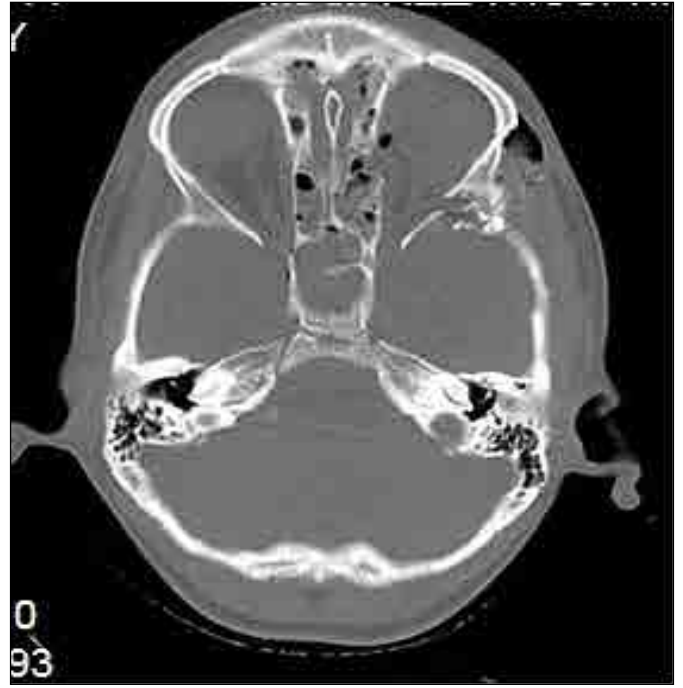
Preoperative skull CT scans.
